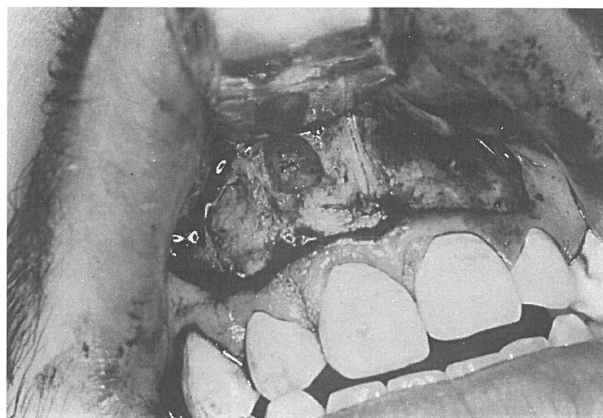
Surgical access to the periapical lesion was achieved by removal of buccal plate to create a window in the bone
